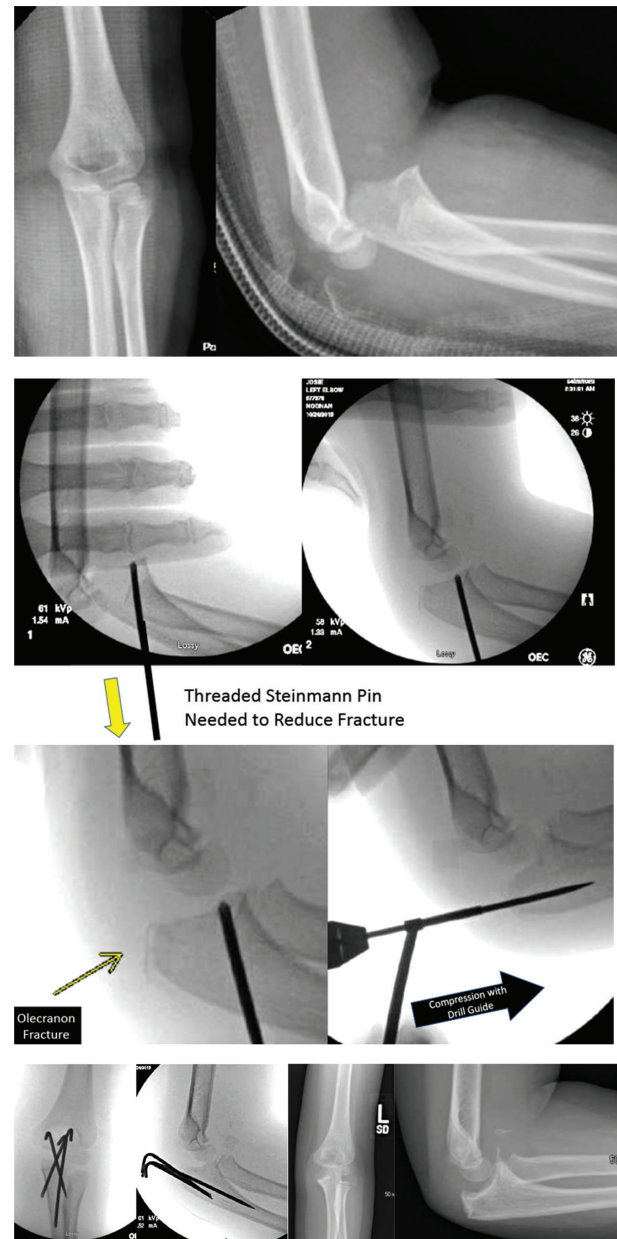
This four-year-old presented with a fracture dislocation of her elbow which was irreducible in the OR. A threaded Steinmann pin in the olecranon facilitated reduction. The olecranon fracture was pinned percutaneously with a drill guide compressing cartilaginous apophysis. Follow-up x-rays showed an excellent result. Multiple K-wires were placed divergently to prevent displacement.
